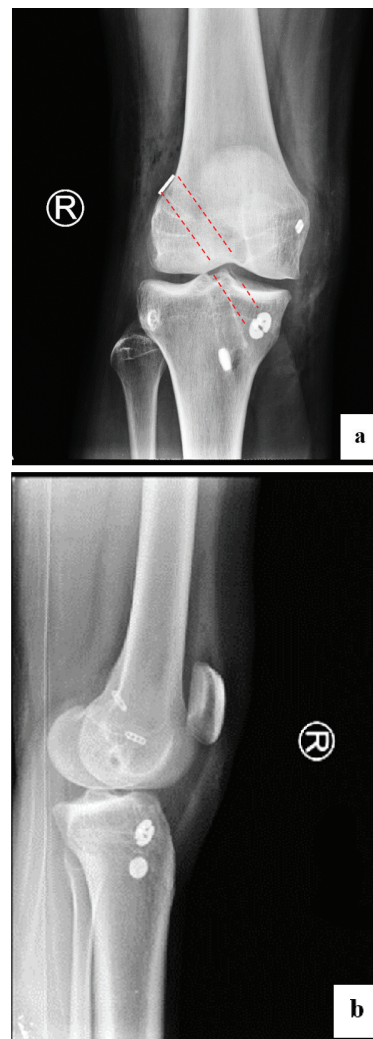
X-ray examination of the right knee joint in straight (a) and lateral (b) projections, dotted lines show the formed bone channels
